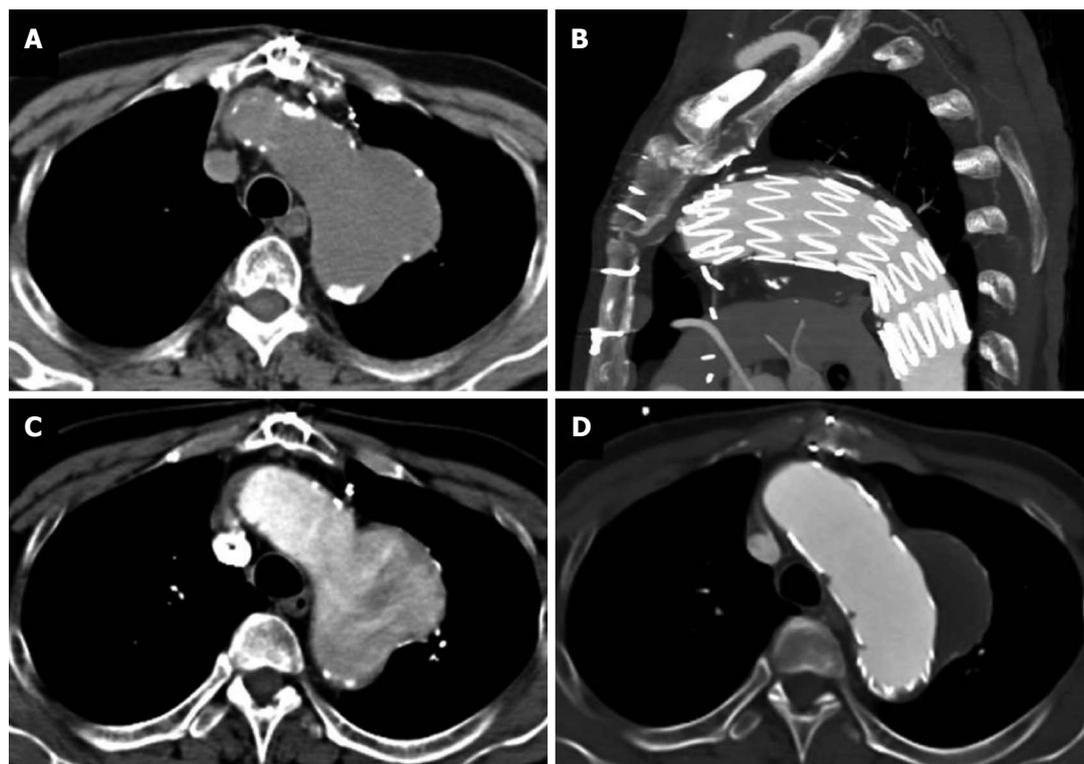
A 68-year-old with chest pain and long standing hypertension. A saccular aneurysm is seen arising from the lateral aortic arch just distal to the origin of the left subclavian artery on this computed tomography aortogram. Atherosclerotic calcifications are seen at the periphery of the aneurysm (A) and there is heterogeneous contrast opacification secondary to turbulent flow on the arterial phase (B). No evidence of rupture is apparent. The aneurysm was excluded using an aortic stent graft as seen in the sagittal plane (C). The excluded sac has completely thrombosed with no endoleak as seen on an axial image (D).
